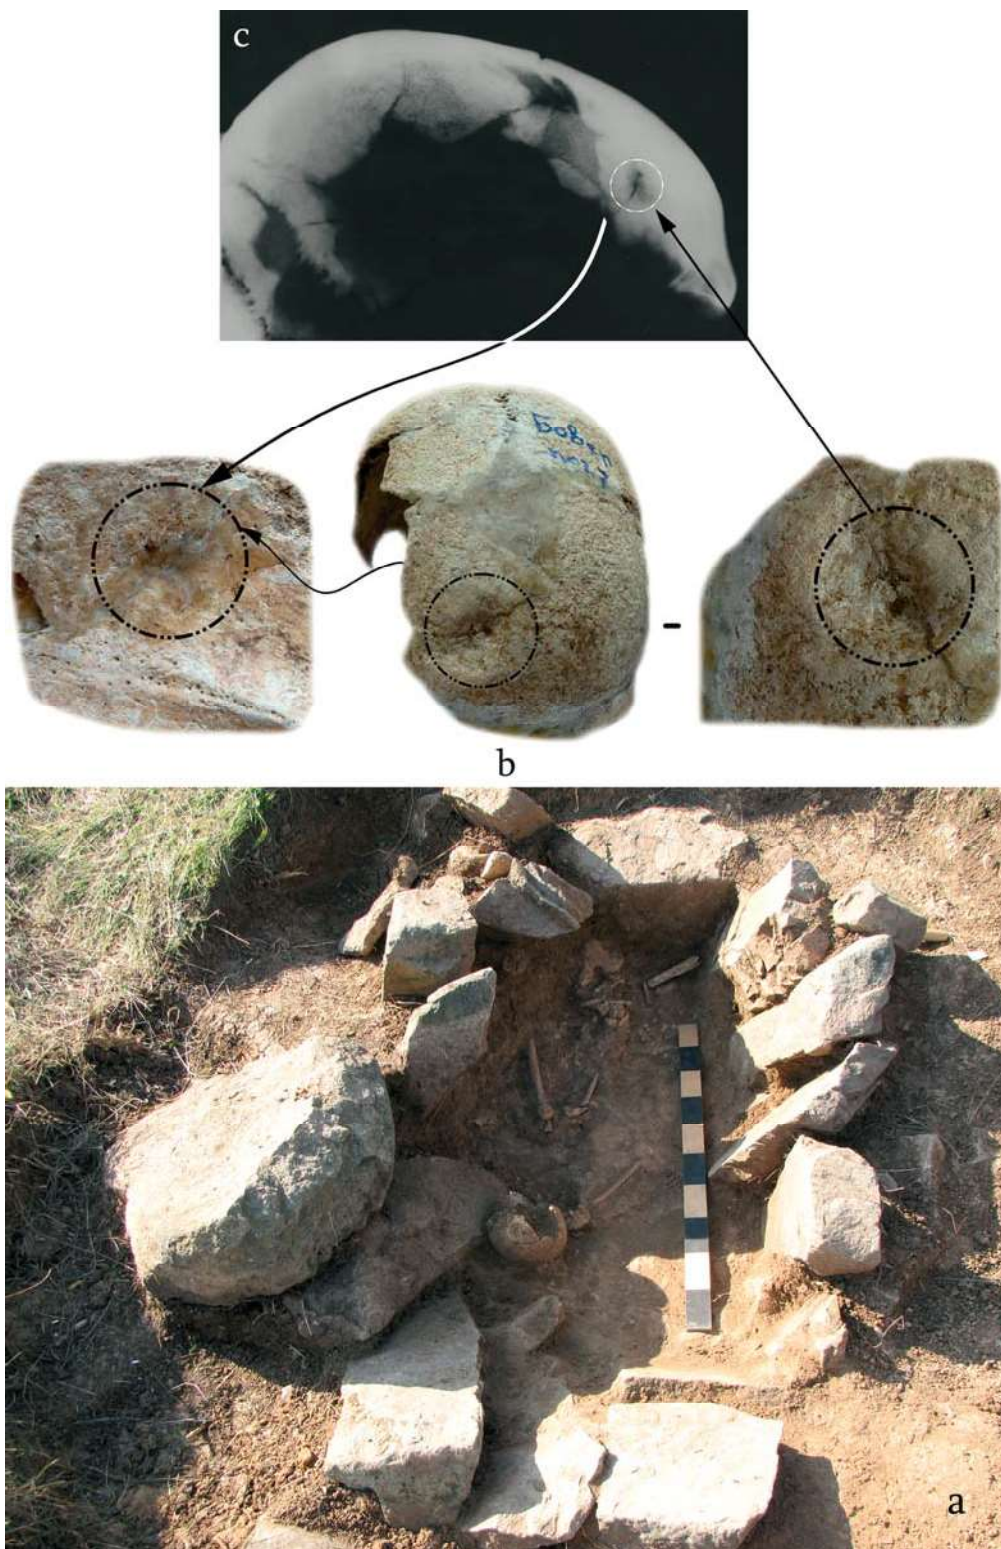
Burial (No. 7). Plan of Burial No 7 (a), surface lesions (trephination), gross morphology (b), X-ray (c).
